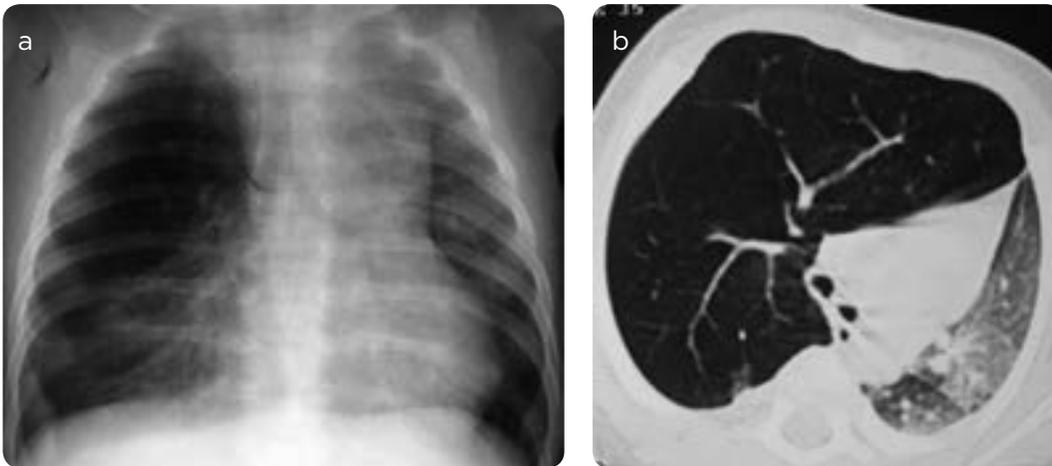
Congenital lobar emphysema. 7-month-old girl. a) Chest x-ray. Radiolucency and hypovascularity in the right pulmonary field. b) CT scan of chest, axial, pulmonary window. Hyperinflation of the right upper lobe with contralateral displacement of the mediastinal structures and passive atelectasis of the left pulmonary parenchyma.
